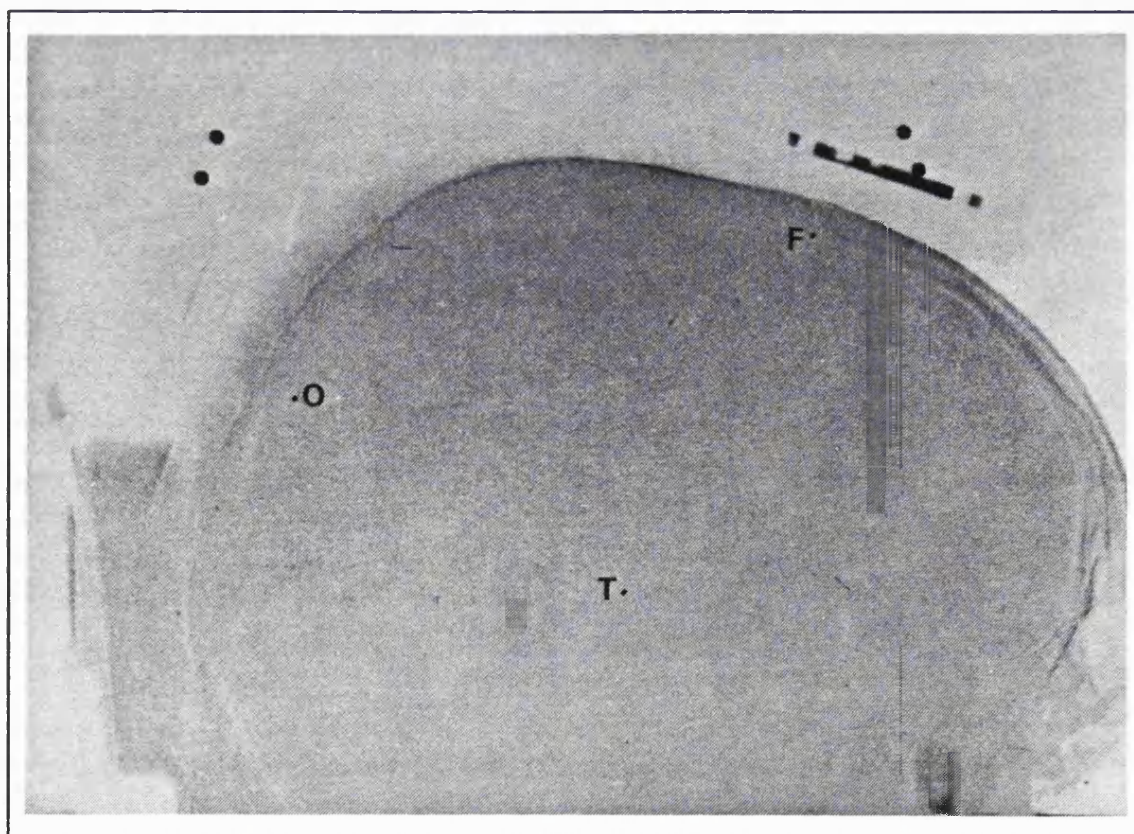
Lateral X-Ray taken after second positioning of the frame superimposed on a mask film taken after the first positioning so that the SGV reference points subtract
